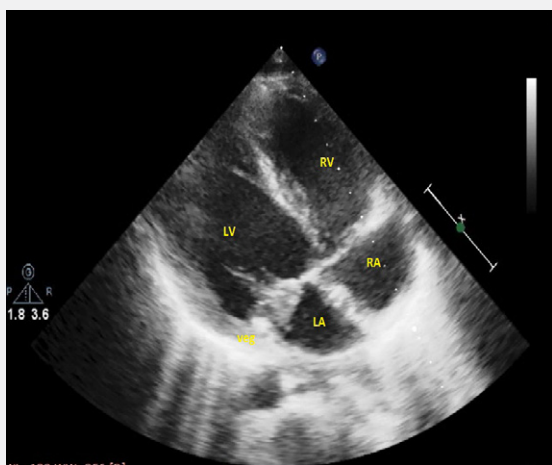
Transthoracic echocardiographic image shows a large vegetation on the mitral valve (veg). RA: Right atrium, RV: Right ventricle, LA: Left atrium, LV: Left ventricle.
